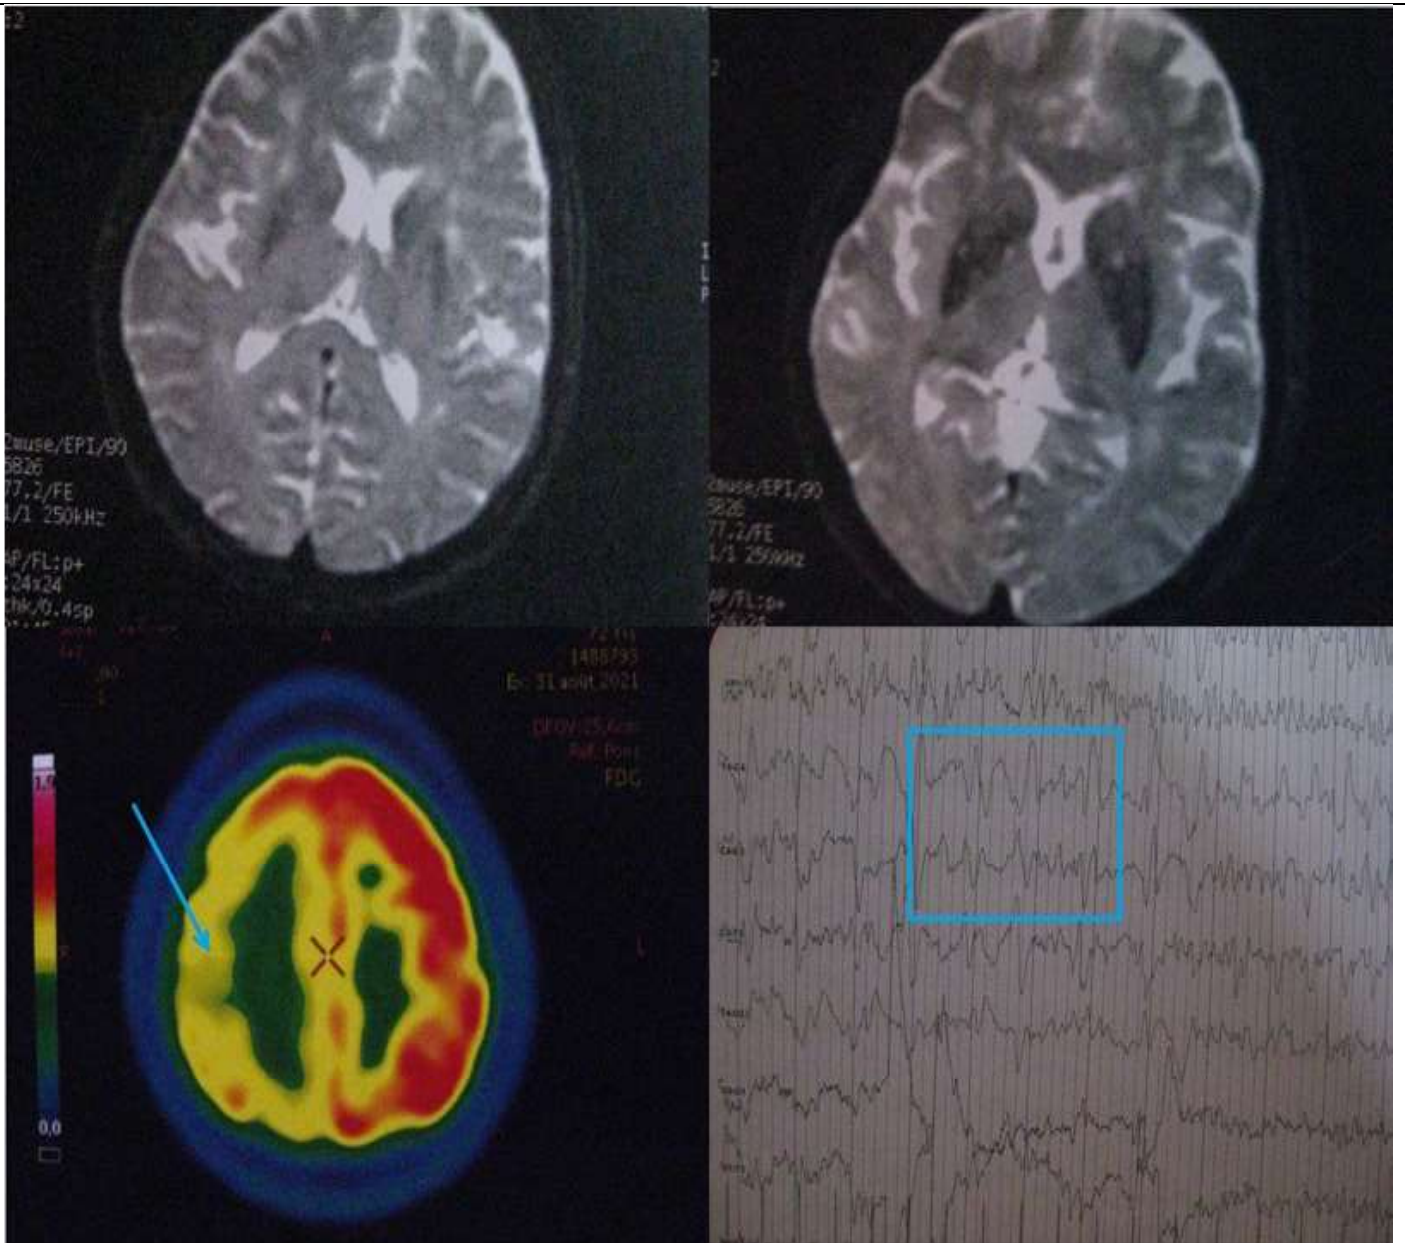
Brain scans of the Princess Doyer: MRI, PET and EEG (D M), Brain MRI (Diffusion Weighted Imaging) and (Fluid-Attenuated Inversion Recovery, FLAIR) and (T2) showing abnormalities of the parietal lobes predominantly on the left side and of the cingulate gyrus. The FDG-PET shows hypometabolism of the right hemisphere predominantly in the right frontal and parietal lobes. The EEG (lower right) shows 6 Hz background activity and 6 seconds of 1 Hz triphasic periodic spikes in the right hemisphere. The blue rectangle in the EEG is a typical proof of Creutzfeldt-Jakob Disease with, in her case, 6 seconds of 1 Hertz triphasic periodic spikes.
